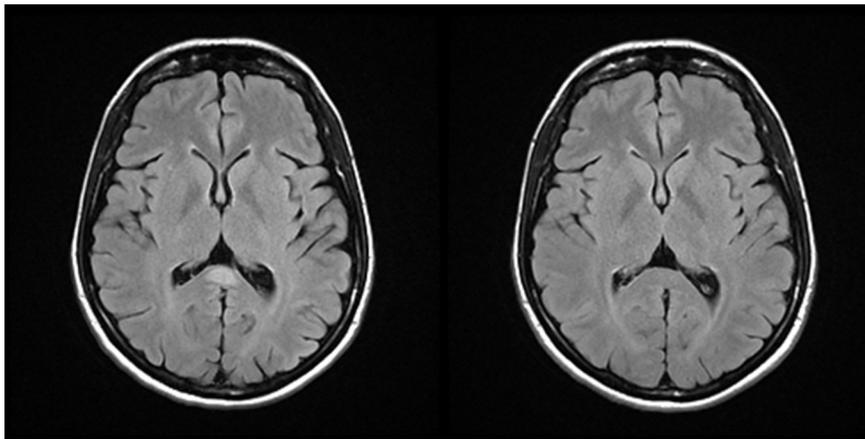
T2 FLAIR images at an initial presentation on the (left) demonstrates high signal within the splenium of the corpus callosum. This corresponds to the high signal on DWI. The splenium is mildly expanded. On follow up on the (right), there is a resolution of the high signal within the splenium and return to more normal size.
